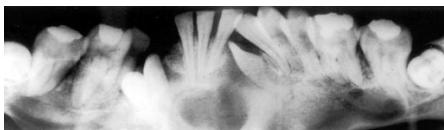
Panoramic radiograph (panorex) showing multiple keratocystic odontogenic tumours / odontogenic keratocysts.
